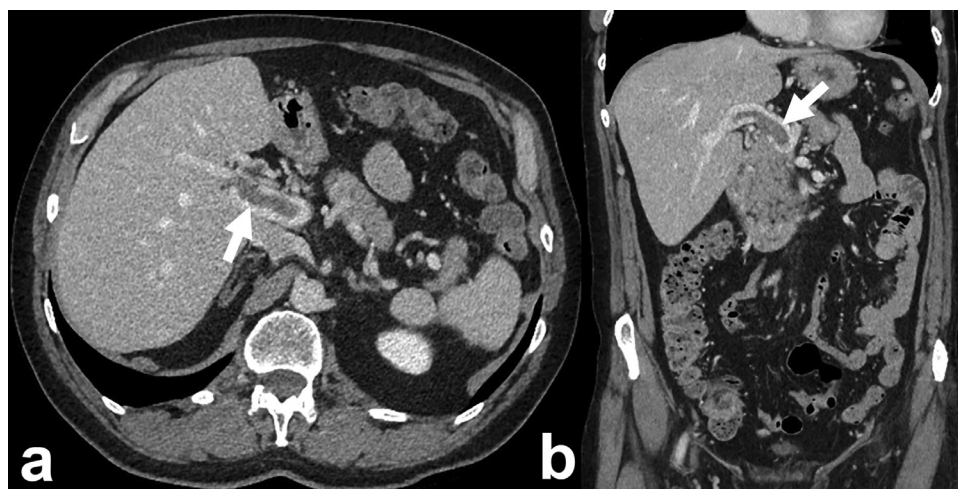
Partial regression of thrombosis of the portal vein and superior mesenteric vein with complete regression of thrombosis (white arrow) in the right and left intrahepatic branches in the CT after 30 days.
